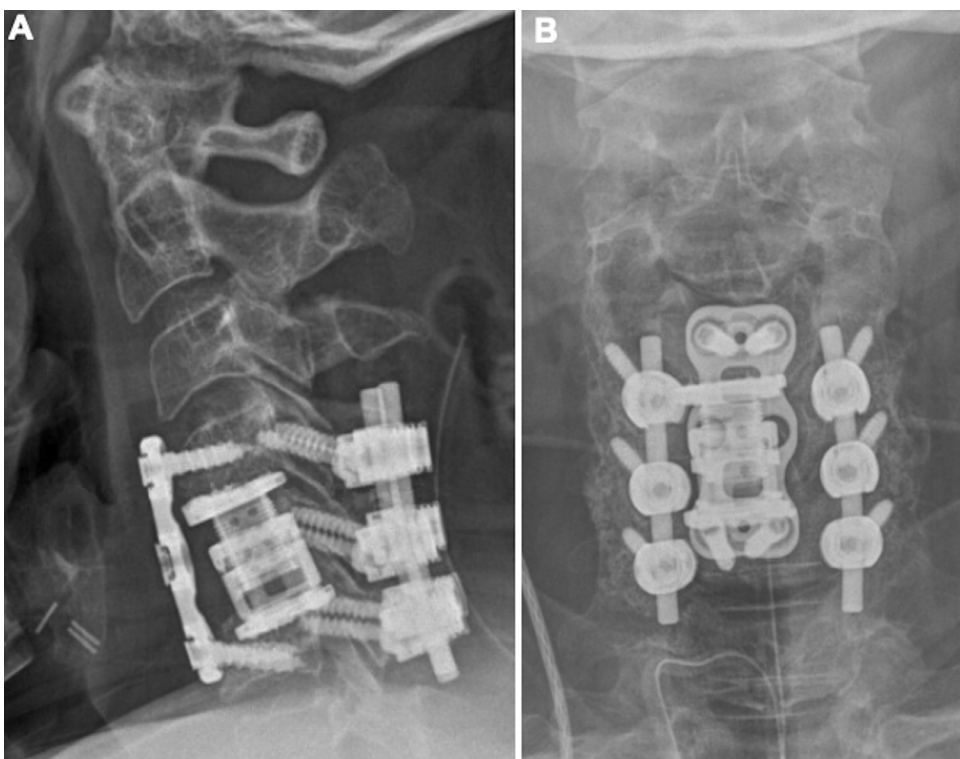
Panel A shows the lateral and Panel B shows AP postoperative radiographs showing no change of the implants after posterior C4–6 instrumentation and fusion.
